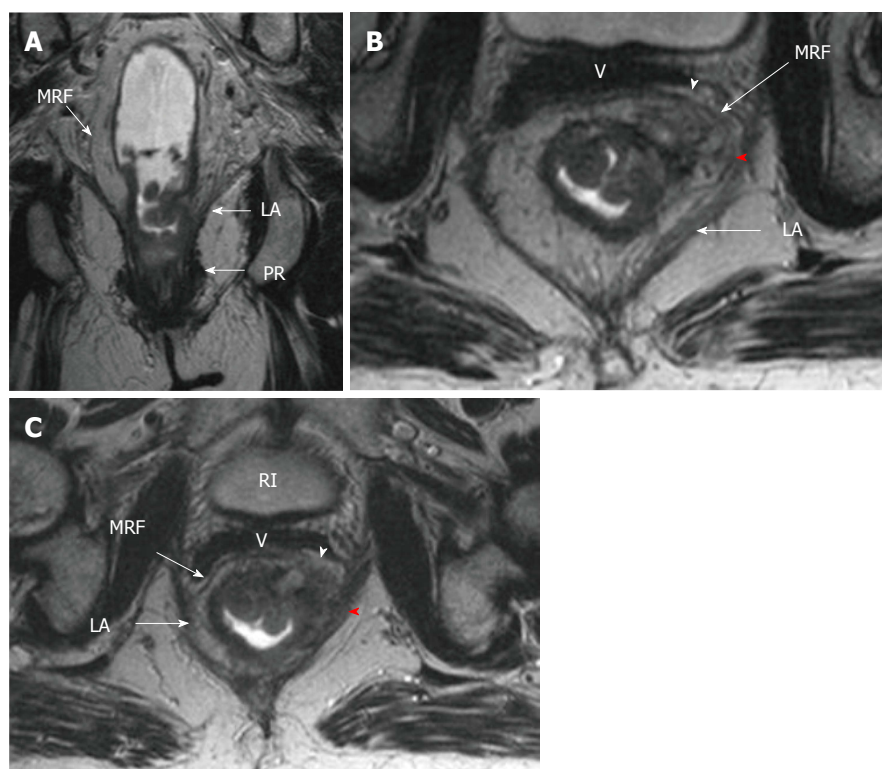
Stage 4 low rectal cancer. On T2-weighted (A) coronal (B, C) serial axial magnetic resonance images, rectal cancer showing invasion of levator ani (red arrowheads) and mesorectal fascia (white arrowhead). LA: Levator ani; PR: Puborectalis; MRF: Mesorectal fascia; BL: Bladder; V: Vagina.
